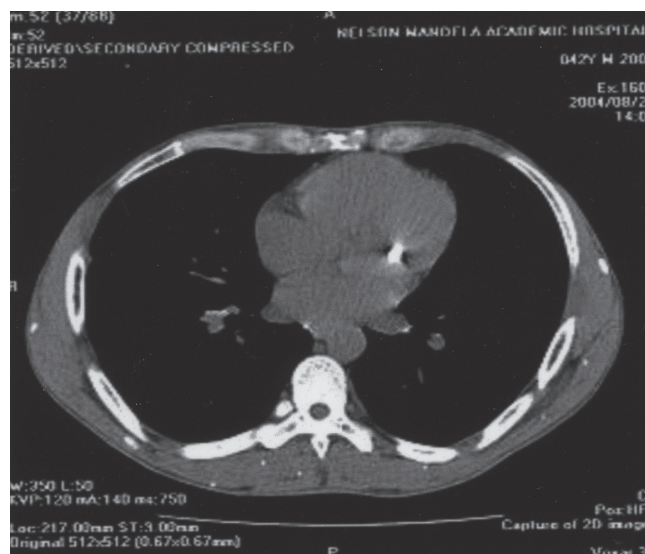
CT scan of the chest showing active cysts within the myocardium.
